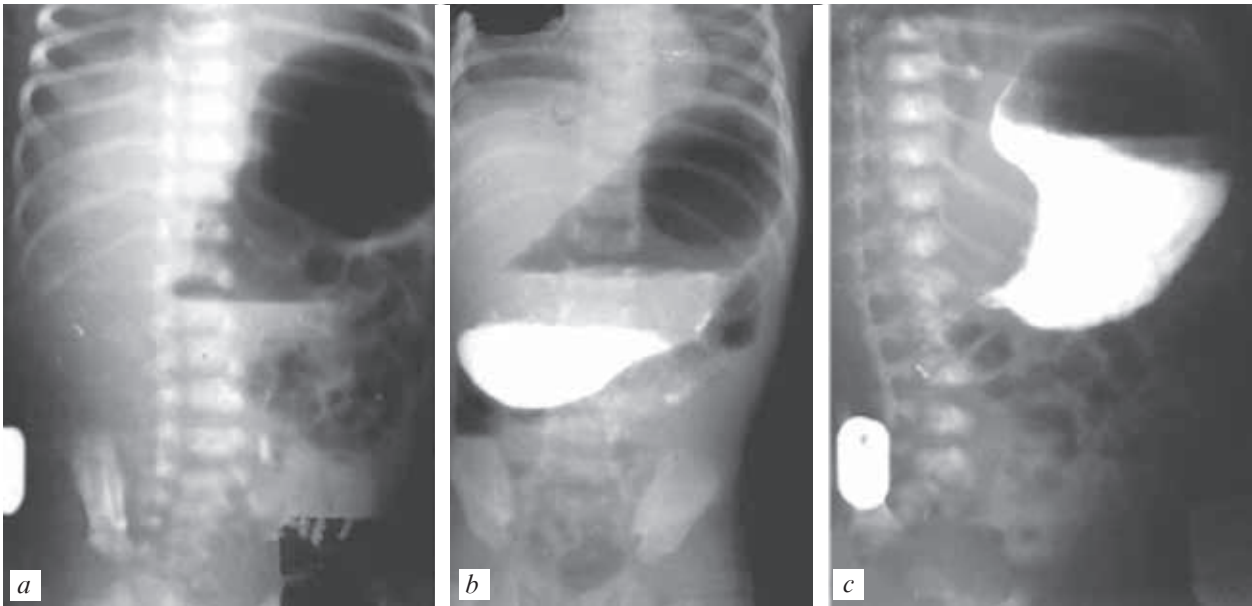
Radiographic signs of pyloric stenosis (a-c)
